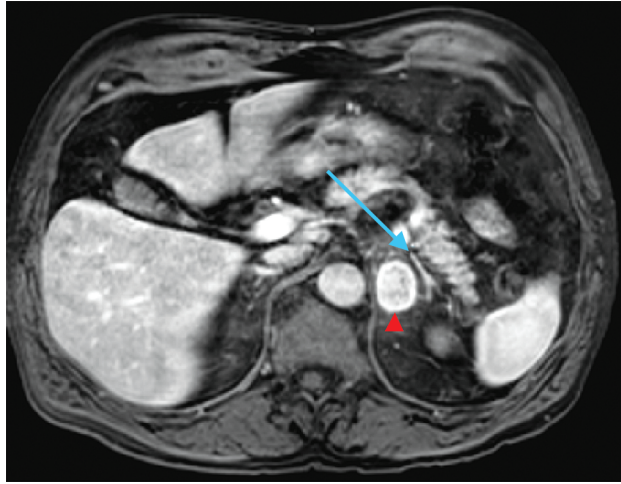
Case 1, MRI transverse section demonstrating rPGL (arrowhead) superomedial to left adrenal gland (arrow)
